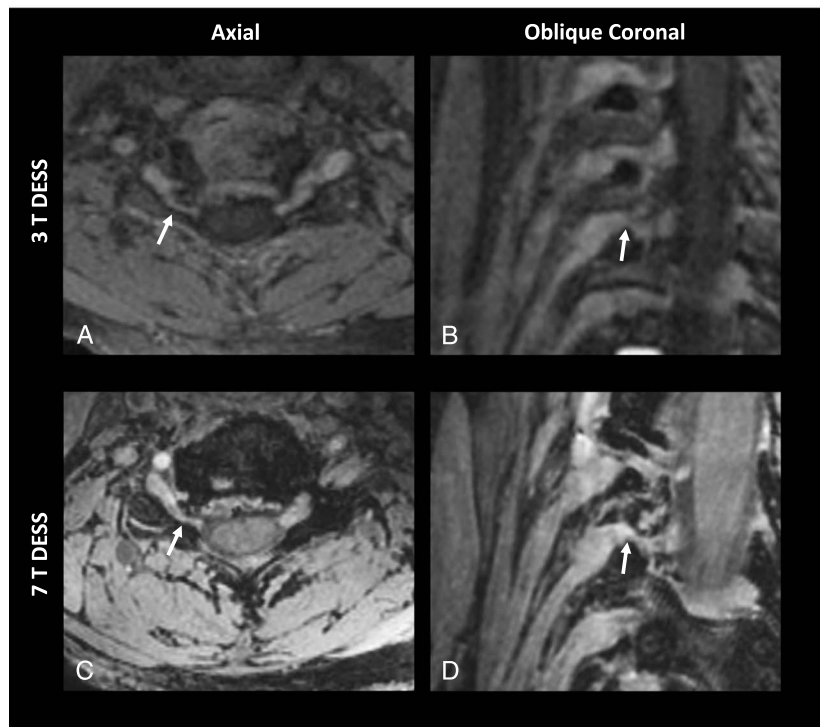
Multiplanar 3D DESS MRI scans of a patient with surgically confirmed neuroforaminal stenosis at the level of C7 on the right side. Multiplanar reformations of the 3D DESS sequence on 3 T MRI (A and B) and 7 T MRI (C and D) directly visualize the compressed cervical nerve root at the level of stenosis (arrows). Note the improved visibility of the nerve root on the 3D DESS images acquired at 7 T.
